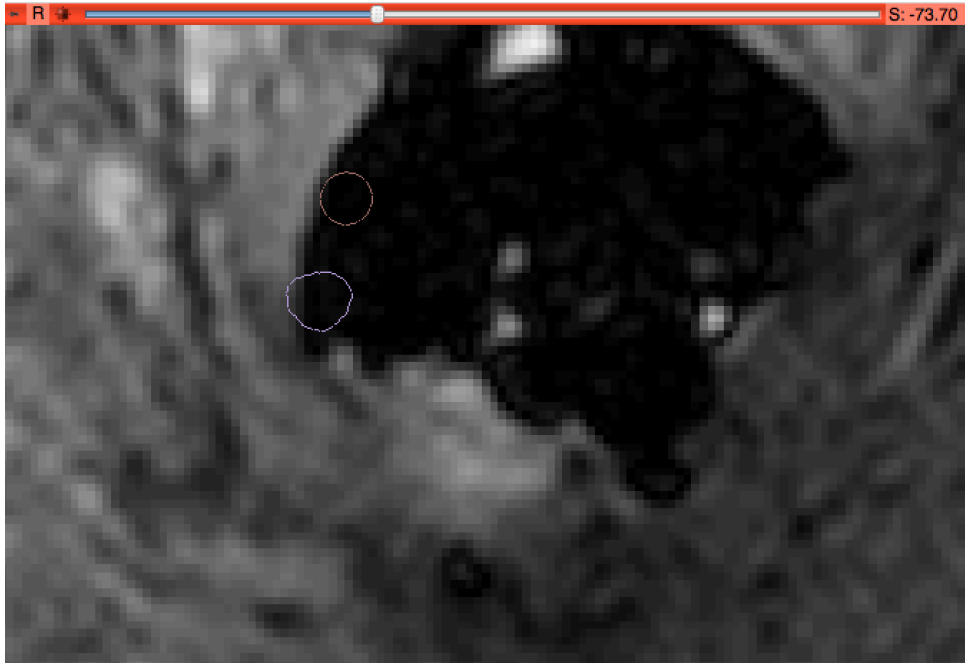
This figure shows an axial view of the MRI dataset and the cross-section of the manually segmented and the automatically segmented needle 5.
